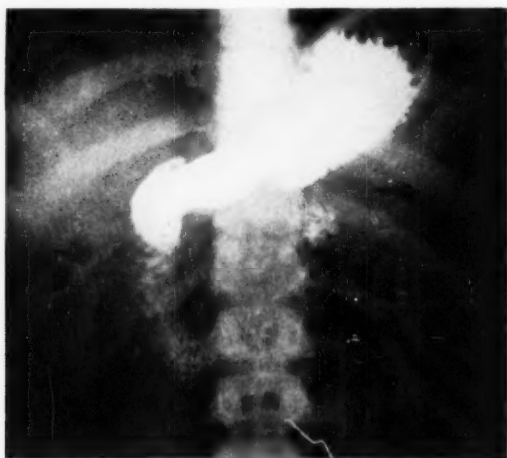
Roentgenogram showing a normal stomach 14 months after operation.
